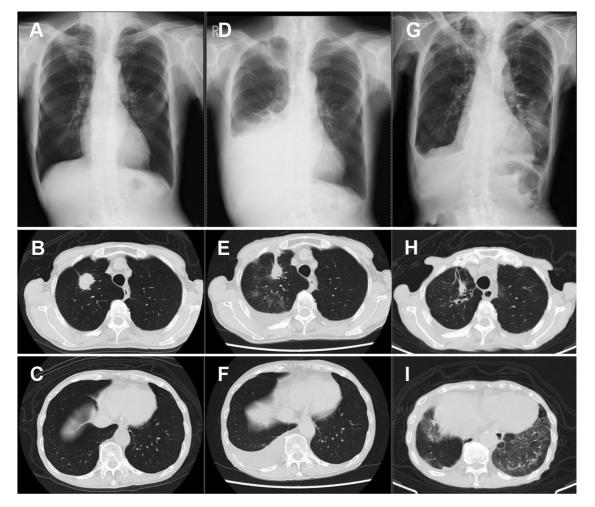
Chest X-ray (CXR) and computed tomography (CT) findings of an 86-year-old man on referral (A-C in March), relapse (D-F in August), and admission (G-I, in December). Both CXR and CT show bilateral ground-glass opacities on admission (G and I).
